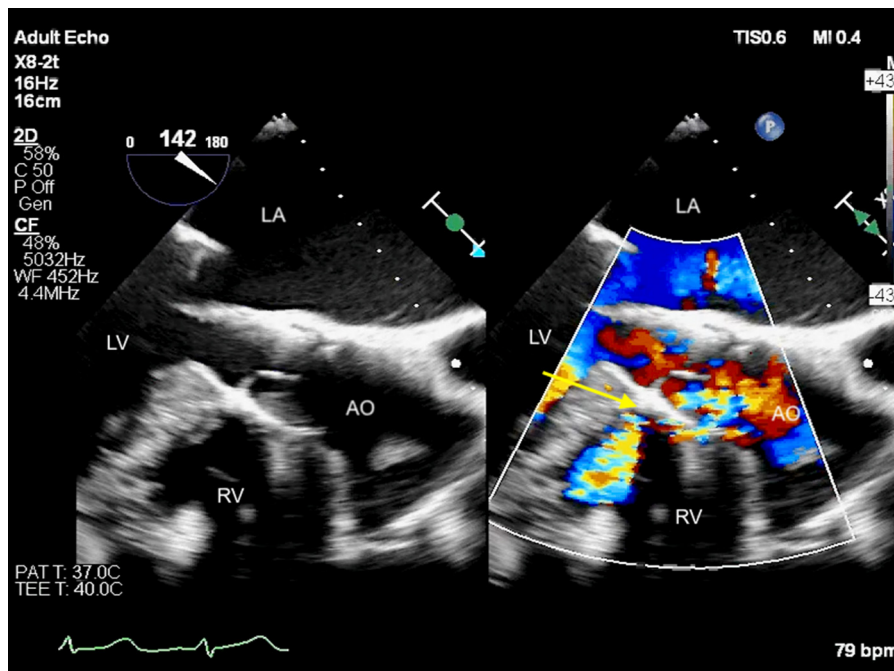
Two-dimensional TEE, zoomed midesophageal long-axis (142°) view without (left) and with (right) color flow Doppler demonstrates a communication between the aorta and the RV with left-to-right shunt (arrow). AO, Aorta; LA, left atrium.
